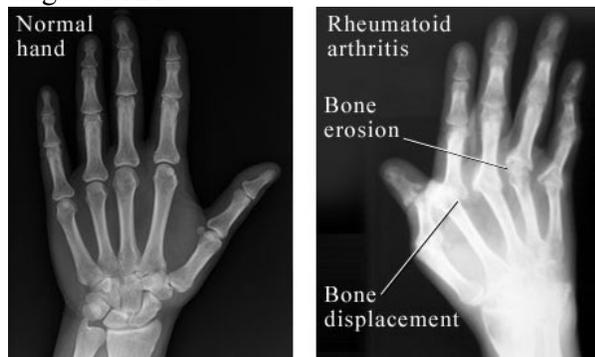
X-Ray changes seen in hand with RA.
